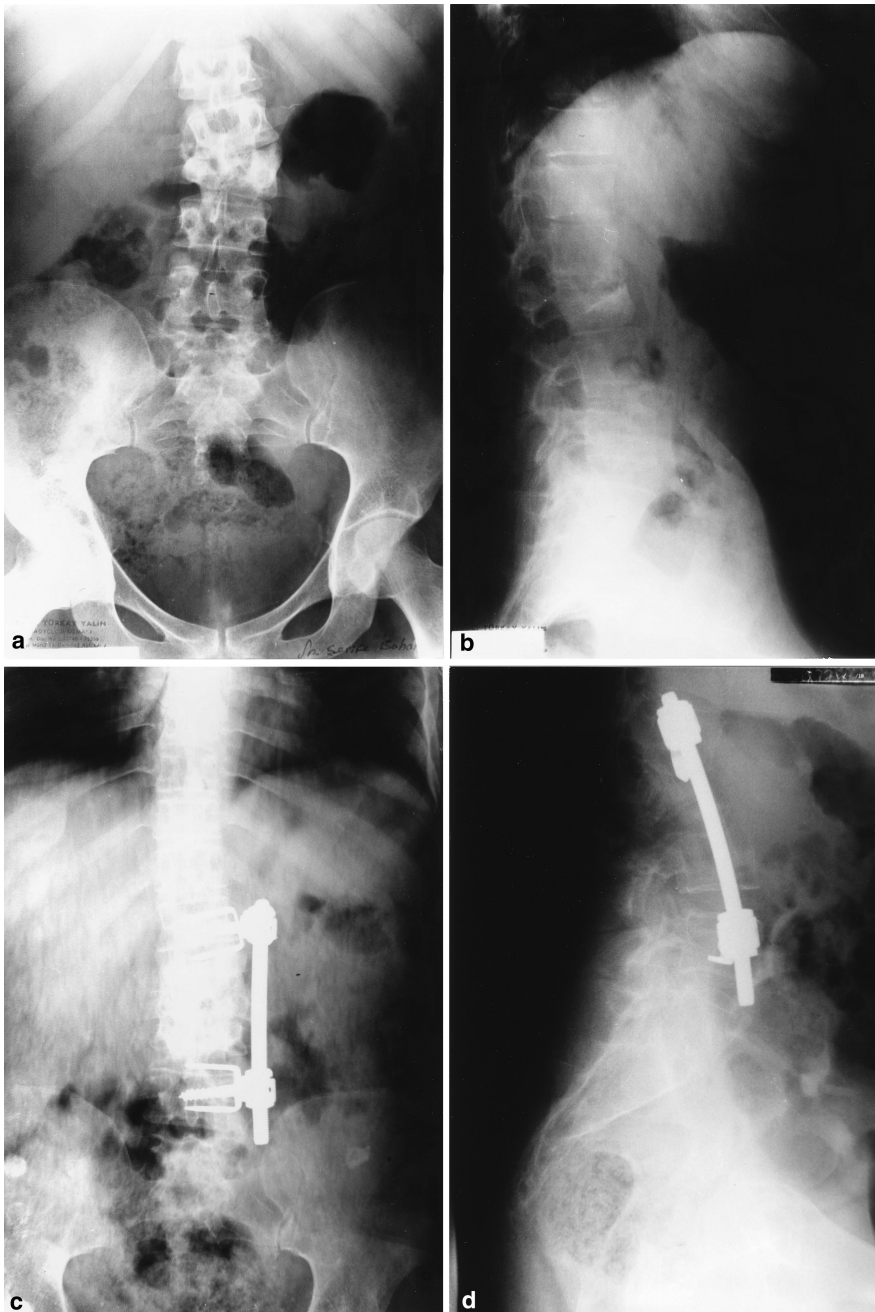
Single level (L3) destruction due to Pott's disease in a 27-year-old woman patient. Preoperative anteroposterior (a) and lateral (b) radiographic findings of the patient reveal instability of the spine. Anterior decompression, intervertebral grafting, and internal fixation comprised the method of treatment. Postoperative anteroposterior (c) and lateral (d) radiologic findings reveal satisfactory results using the AICI spinal system.
